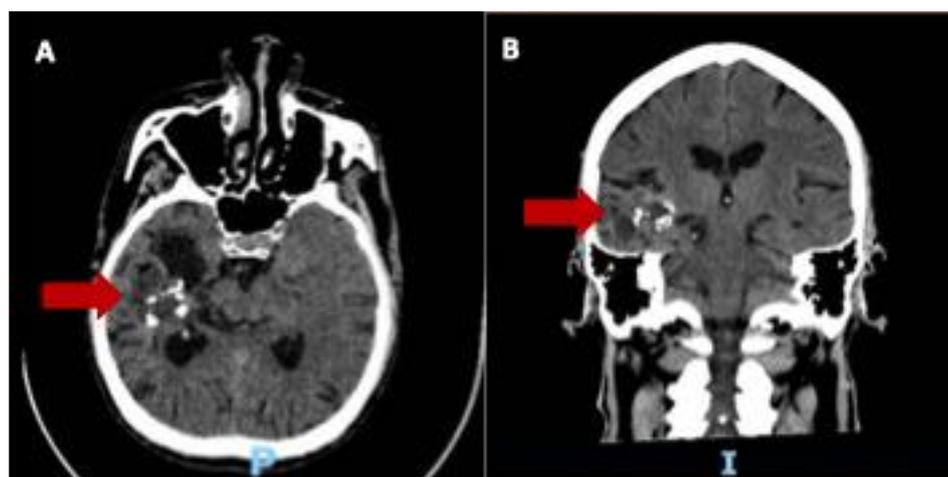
Non-contrast head CT scan. In the axial (A) and coronal (B) sections, there is an ill-defined hypodense lesion with multiple calcifications in the right temporal lobe
